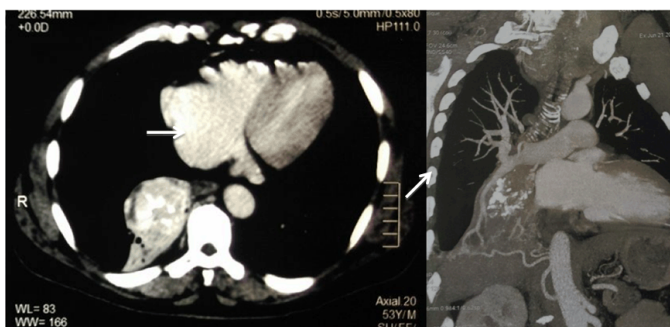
(A) Computed tomography scan of chest with contrast revealed right lower opacity, and (B) Chest angiography with appearance of the aberrant blood supply of pulmonary sequestration.
